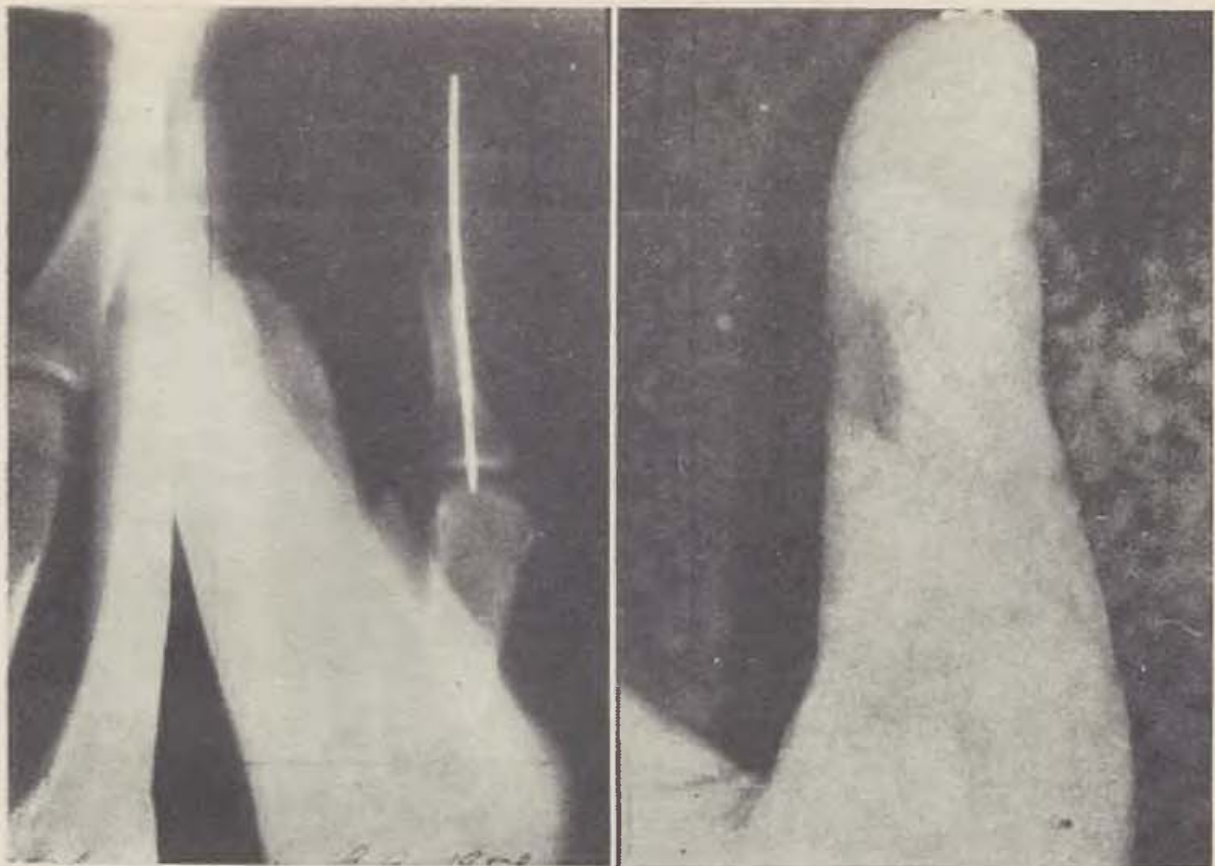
The same patient. X-ray of the thumb with K-wire introduced. — Fig. 6. The same patient. Effect of treatment after 6 months
